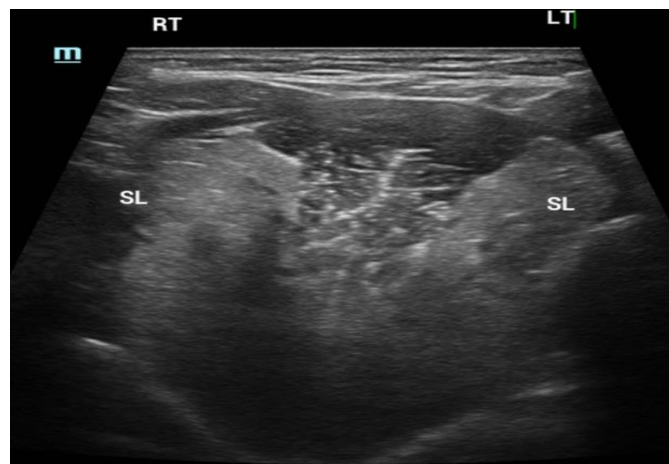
Transverse sonogram showing bilateral hypertrophied sublingual glands.
